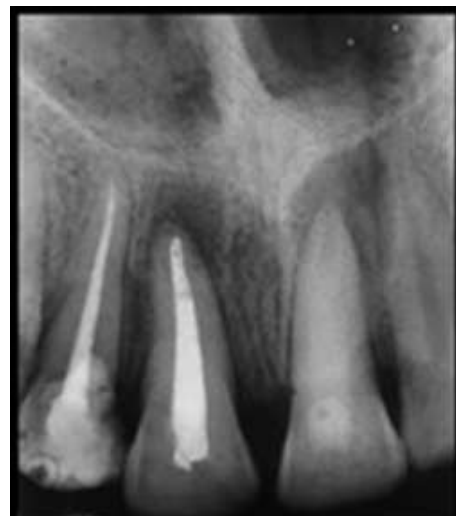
Post-obturation IOPA radiograph
